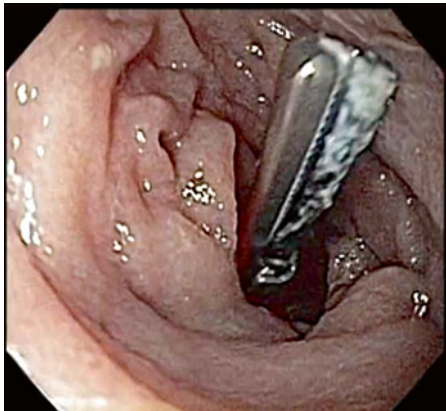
Endoscopic view of laparoscopic ultrasonic device.
